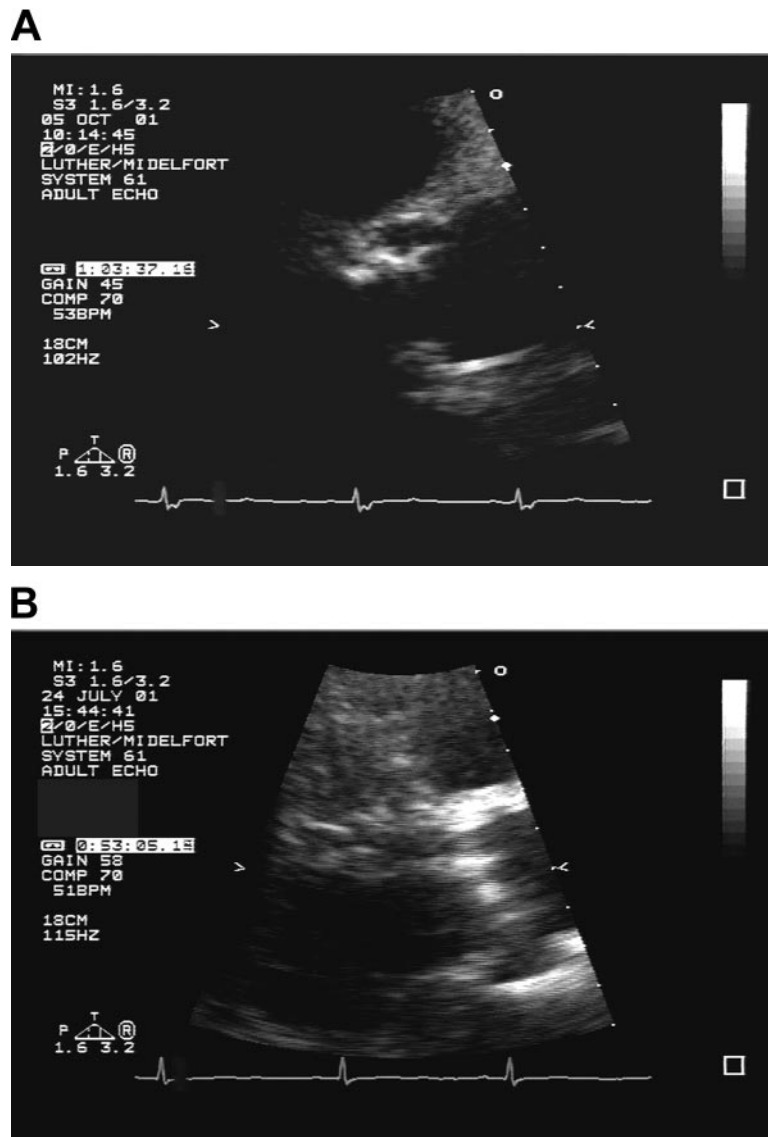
Preoperative transthoracic echocardiogram showing heavily calcified aortic valve (A) paired with same patient with postoperative transthoracic echocardiogram showing properly functioning prosthesis (23-mm Medtronic Hall prosthesis; Medtronic, Minneapolis, MN) with NextStitch used as the suture material (B). Note that there is no evidence of ring-down or acoustic shadowing specifically related to the NextStitch material.
